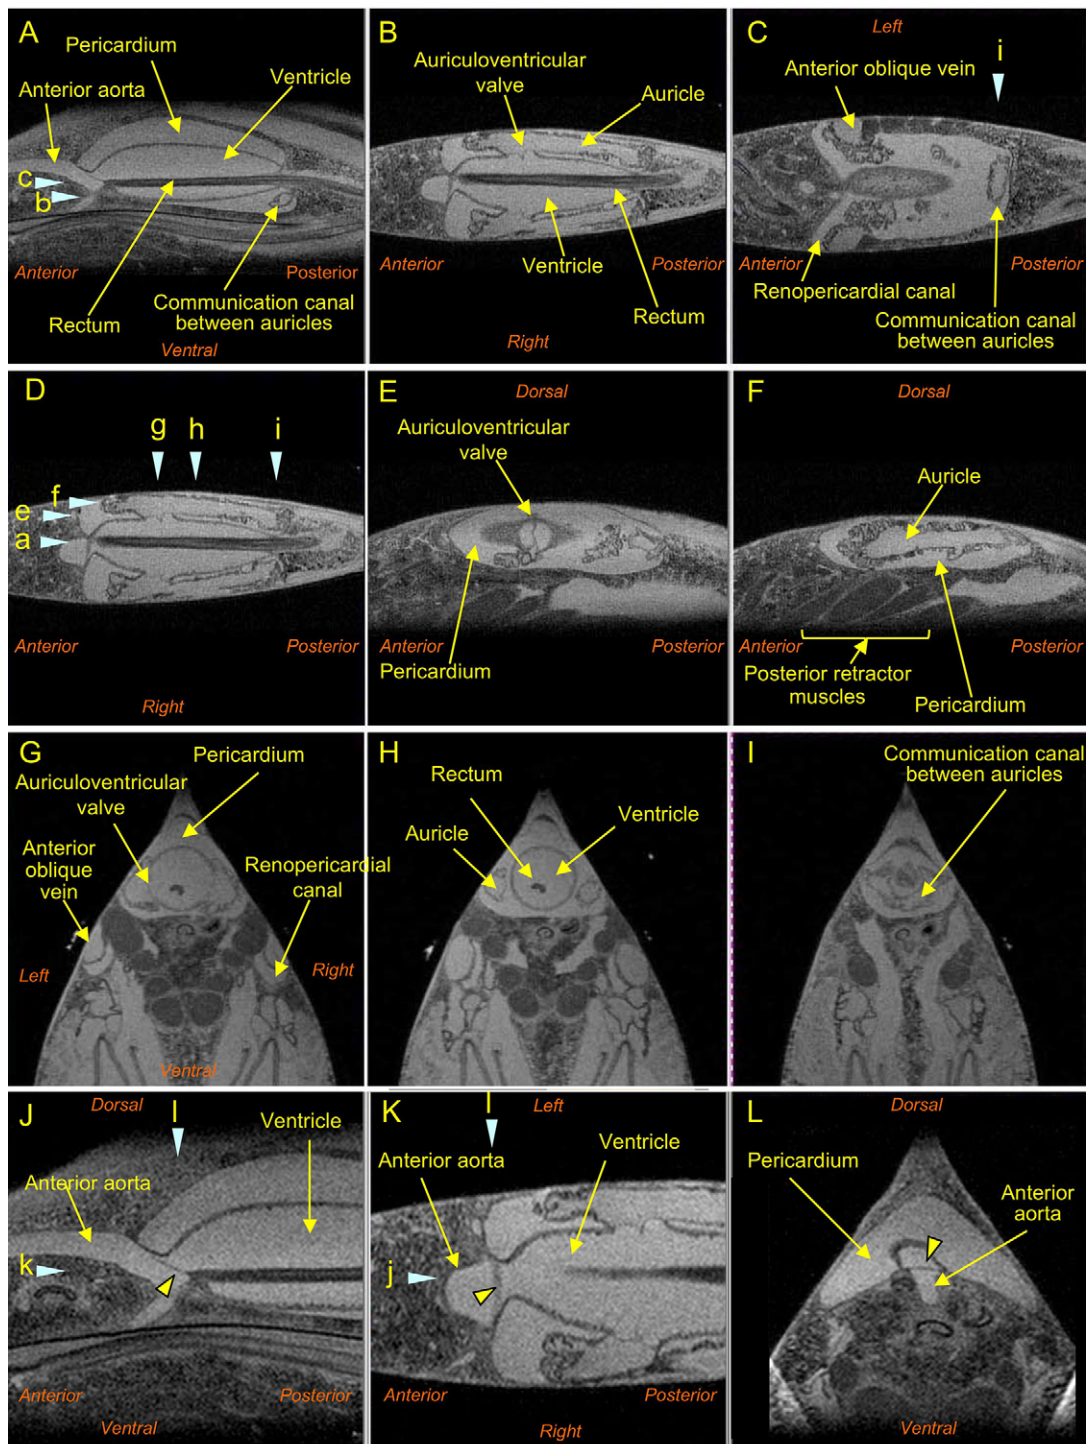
T_{2w} -MR images of *M. galloprovincialis* fixed by PFA. (A) Mid-longitudinal image around the heart. Arrowheads b and c indicate the slice positions (or planes) of the images shown in B and C, respectively. (B) Horizontal image at the level of the rectum. (C) Horizontal image at the level of the communication canal between the auricles. (D) Horizontal image showing the slice positions of A and E–I using arrowheads labelled a and e–i. (E) Longitudinal image of the left auriculoventricular (AV) valve. (F) Longitudinal image of the left auricle. (G) Transverse image at the AV valve. (H) Transverse image at 1.2 mm posterior to the AV valve. (I) Transverse image at the communication canal between the auricles. (J–L) Mid-longitudinal, horizontal and transverse images around the aortic valve. The yellow arrowhead indicates a flap of the aortic valve. Blue arrowheads, labelled j–l, represent the slice positions of images J–L.
